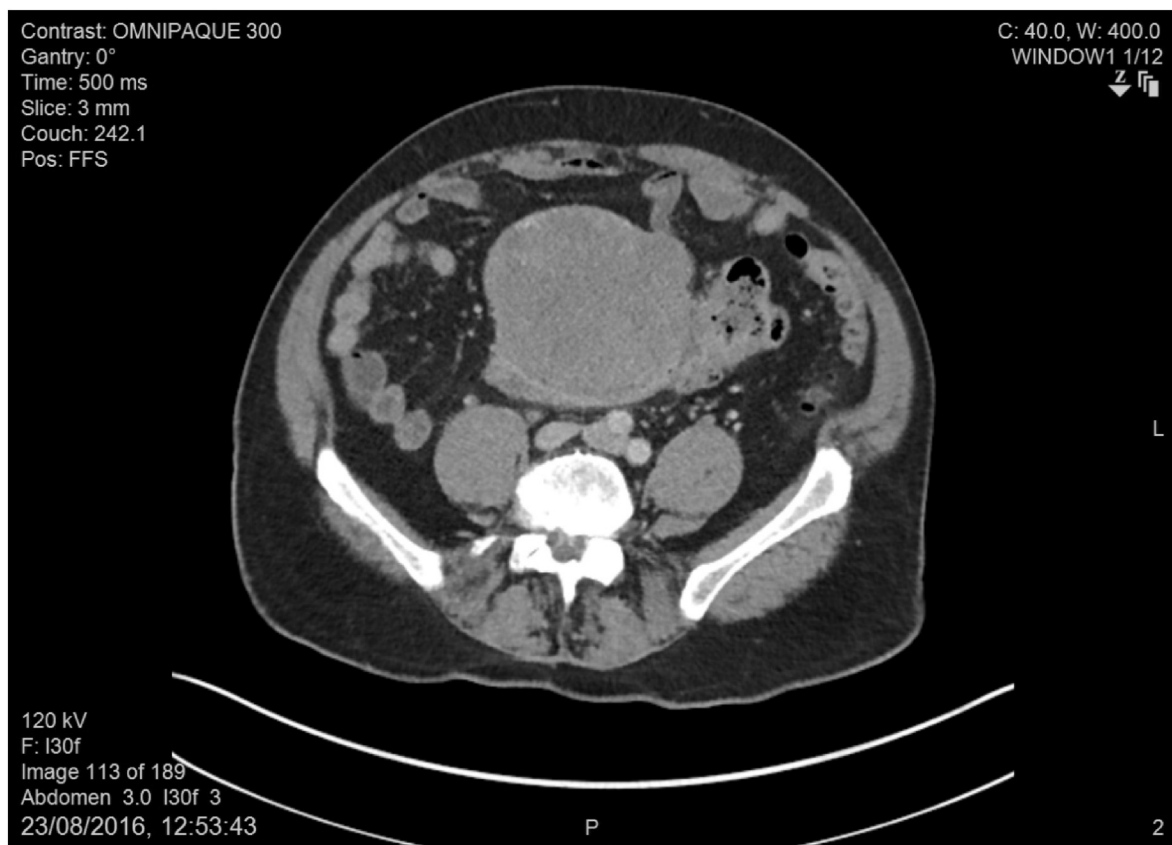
CT scan: fibroid tumour arising from colonic wall.
